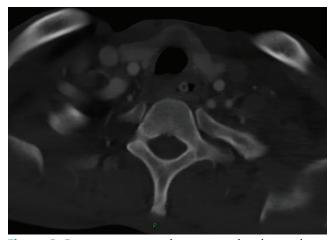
Repeat computed tomography showed the disappearance of the sclerotic vertebral body enhancement.
